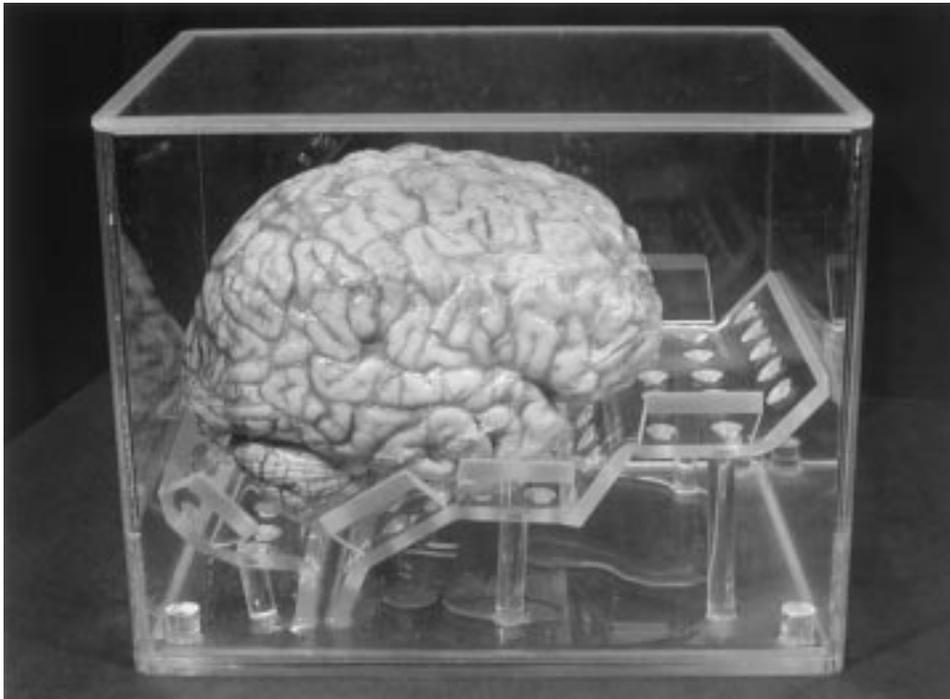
Post-mortem brain in Plexiglas container ($22 \times 17 \times 17$ cm) constructed for MRI. The brain is supported by platforms to maintain alignment along the horizontal axis between anterior and posterior commissures (AC-PC).
